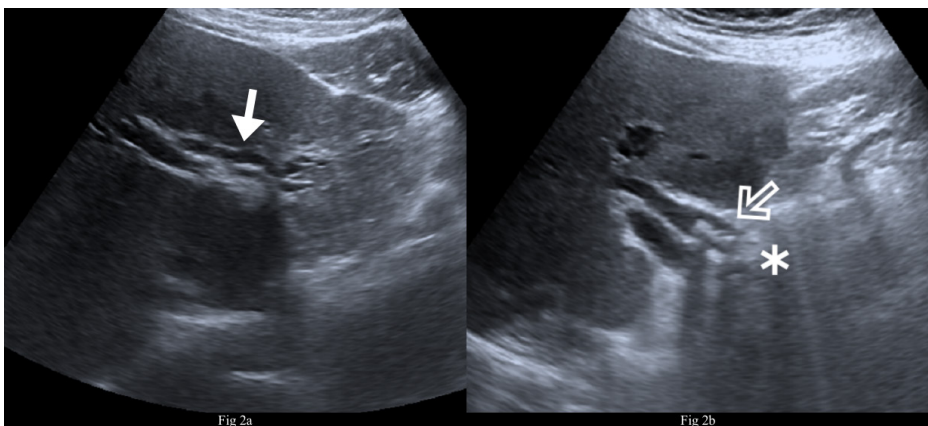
(a) Ultrasonography shows dilated left hepatic bile ducts (white arrow) and (b) dilatation of the CBD and stones in the proximal part of CBD (hollow arrow). The distal part of the CBD could not be visualized due to gastric and intestinal gases (asterisks).
